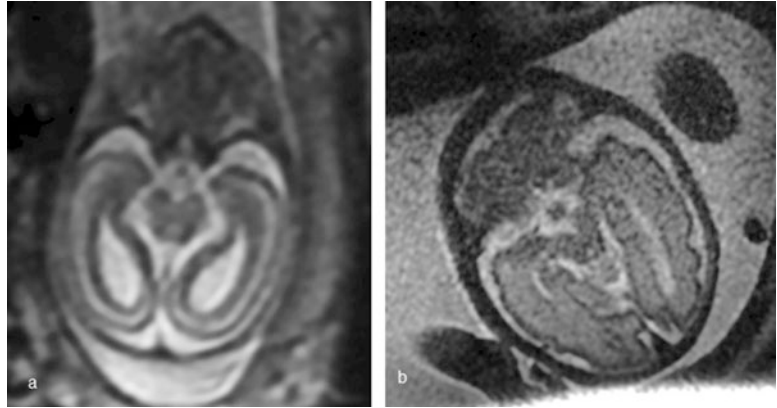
Axial T2 weighted MRI at the level of the lateral ventricles. (a) is a 20 week GA fetus and (b) is a 30 week GA fetus. *White arrows* indicate the choroid plexus. Note the decreasing subarachnoid space and increasing gyration of the cerebral hemispheres
